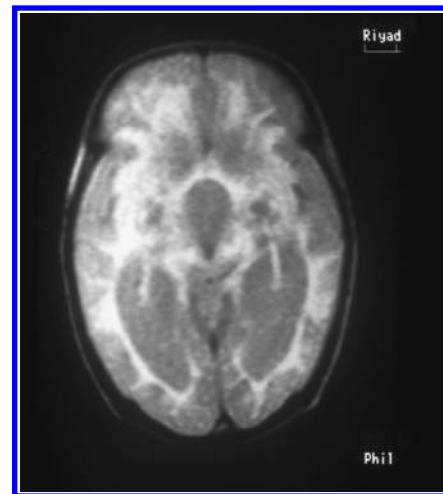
Magnetic resonance image of a patient with PTPS deficiency. There was increased T_1 signal intensity in the frontal lobe.
